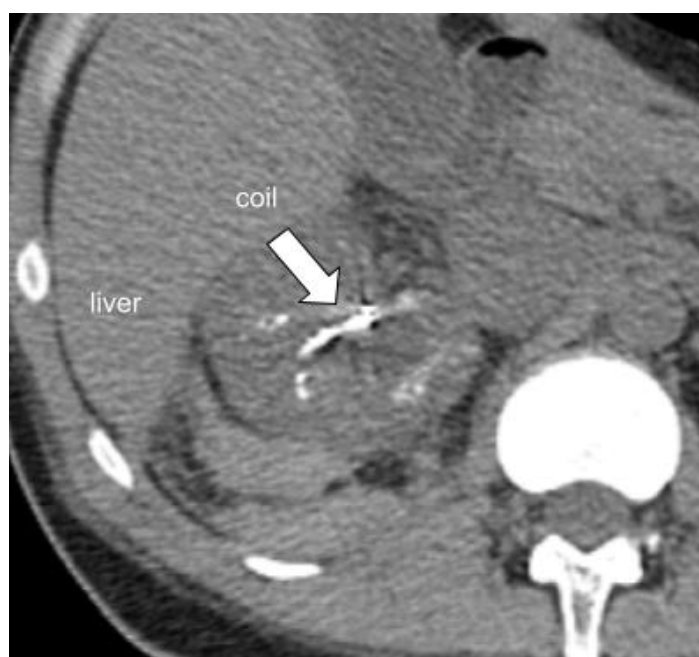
CT post endovascular procedures and hemorrhage control – coil with metallic density.
